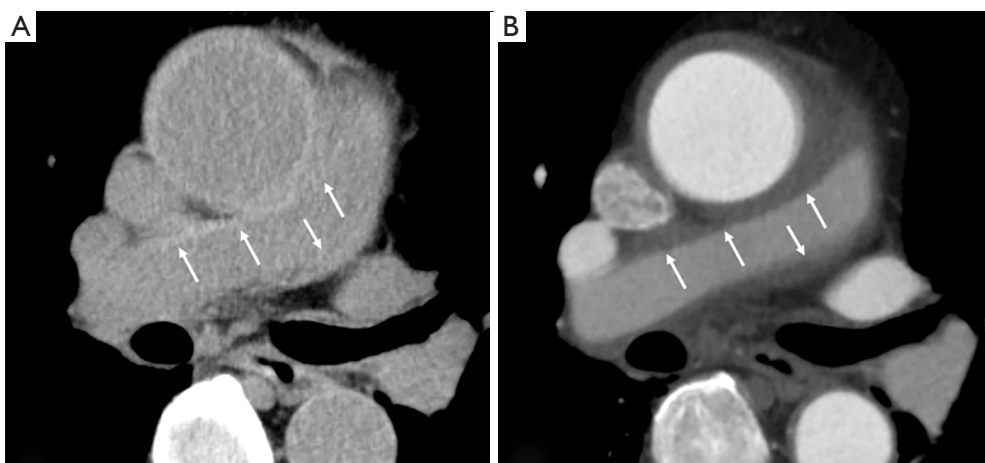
Images for a 76-year-old man with Grade 1 PAPH. (A) Non-enhanced CT showing a higher attenuation area than that of blood along the wall of the pulmonary trunk and right main PA (white arrows); (B) CECT showing no contrast enhancement within the area (white arrows). This was considered a hematoma due to PAPH. PAPH, pulmonary artery periaortic hematoma; CT, computed tomography; PA, pulmonary artery; CECT, contrast-enhanced CT.
